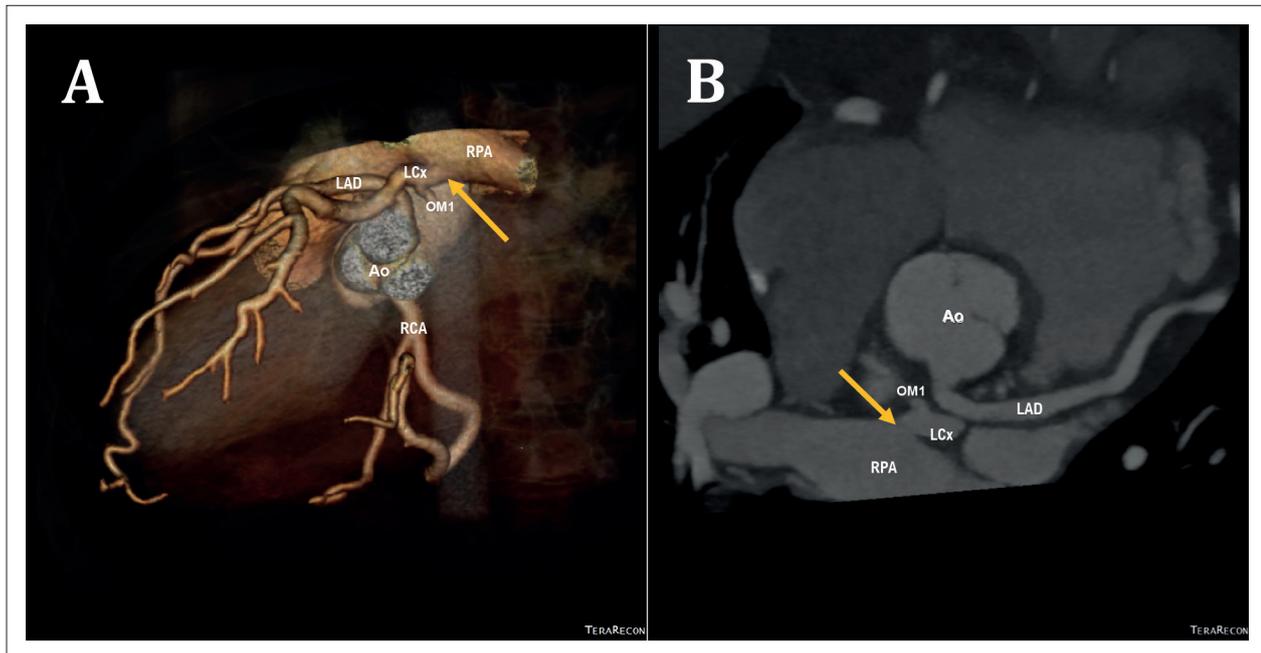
Multislice cardiac CT using a 64-slice scanner showing anomalous origin of the circumflex coronary artery from the right pulmonary artery (arrow). LCx: left circumflex coronary artery; LAD: left anterior descending artery; RPA: right pulmonary artery; Ao: aorta; RCA: right coronary artery; OM1: first obtuse marginal.
